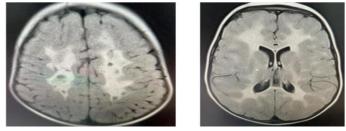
Cerebral MRI, Supra and infratentorial white matter signal change related to the metachromatic leukodystrophy
